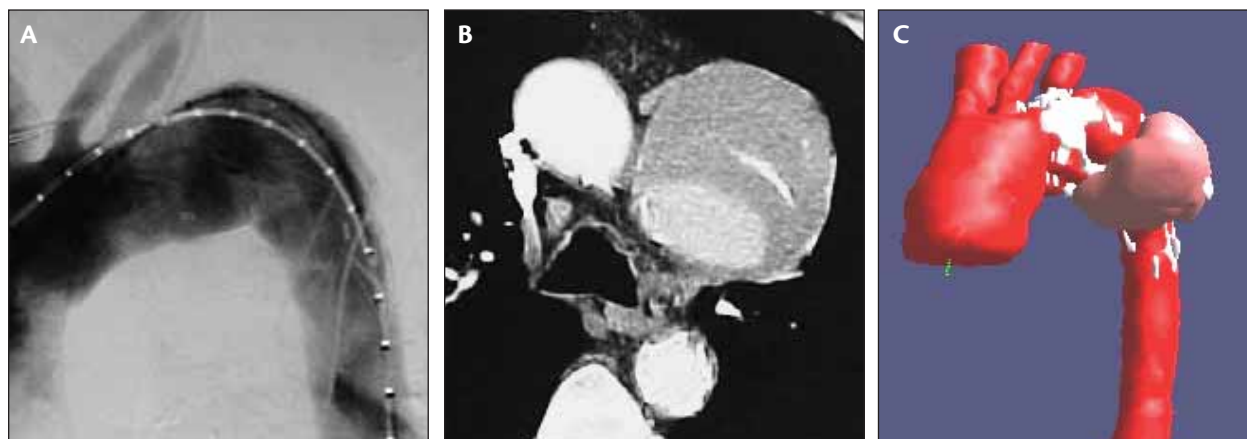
Angiographic result (A) and postoperative CT image (B) and three-dimensional reconstruction (C) confirming presence of a significant endoleak.
